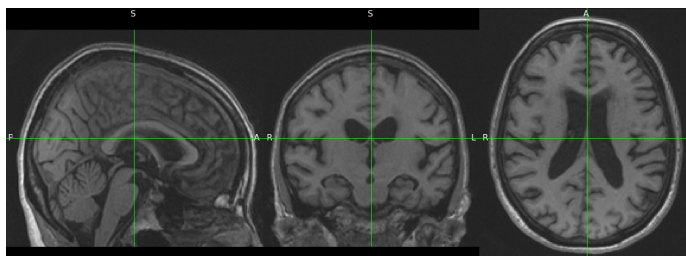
MRI after registration
